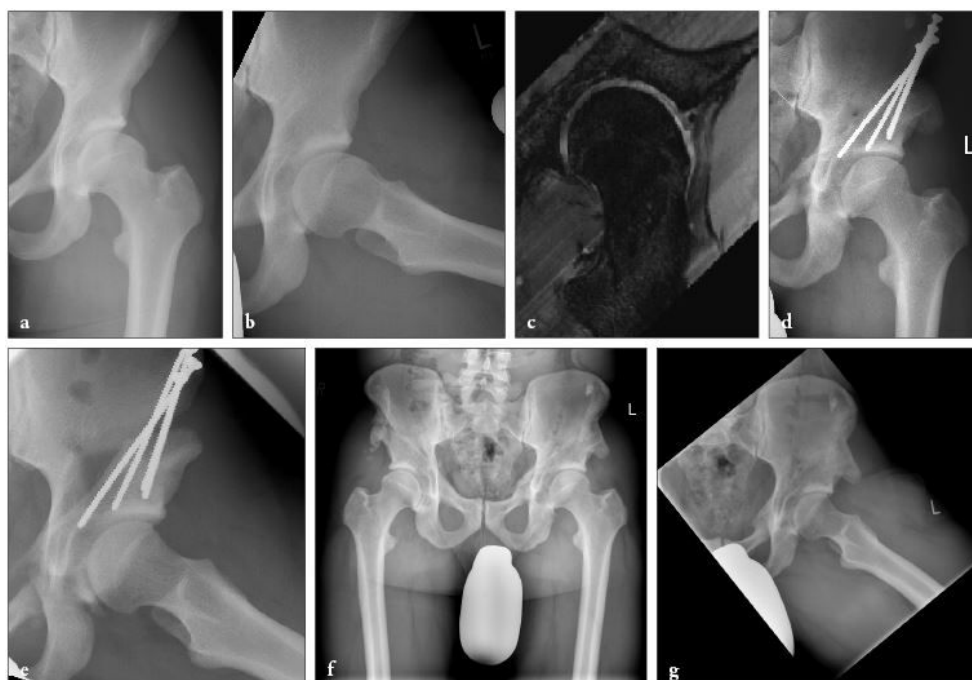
Combined AD and cam-FAI with pre-op radiographs (8a, b), pre-op radial MRI (8c), postoperative radiographs after PAO with cam resection and microfracturing (8d, e) and final result after 12 years (8f, g)
